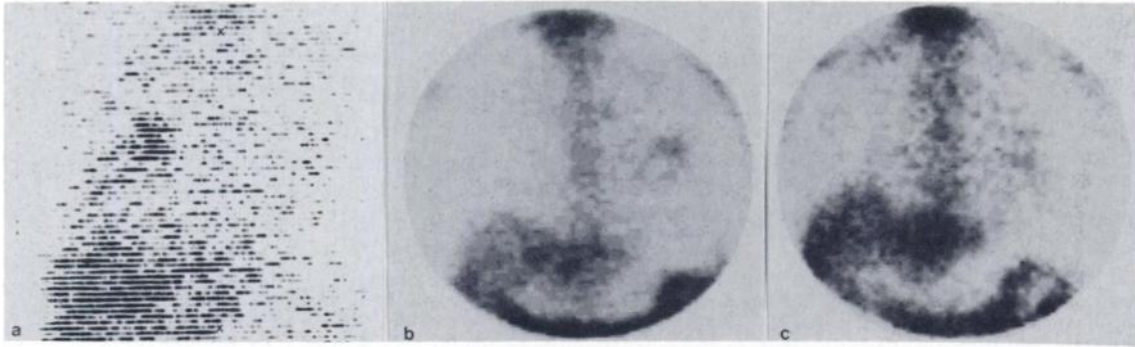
Case 1: Ga-67 lung scintigrams, (anterior view): (a) focus in R lung while on amiodarone treatment; (b) focus in L lung after re-challenging with amiodarone; (c) almost complete disappearance of L focus after subsequent withdrawal.
